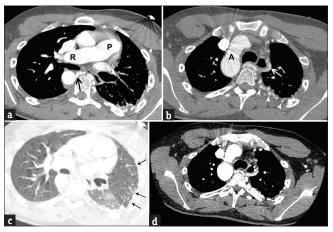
A 31-year-old man with 22q11.2 deletion syndrome who presented for evaluation of vascular anomalies. (a) Contrast-enhanced computed tomography of the thorax axial image demonstrates the main pulmonary trunk (P) giving rise to the right pulmonary artery (R) with the absence of the left pulmonary artery and hypertrophied collateral left bronchial artery (black arrow). (b) Computed tomography axial image demonstrates a right-sided aortic arch (A) and hypertrophied collateral left intercostal arteries (white arrow heads) and bronchial artery (white arrow) supplying the left lung. (c) Computed tomography axial image in lung window shows reticular opacities penetrating the peripheral left lung parenchyma representing intercostal artery collaterals (arrows). The left lung is slightly smaller compared to the right. (d) Computed tomography axial image shows no discernible thymic tissue in the anterior mediastinum.
